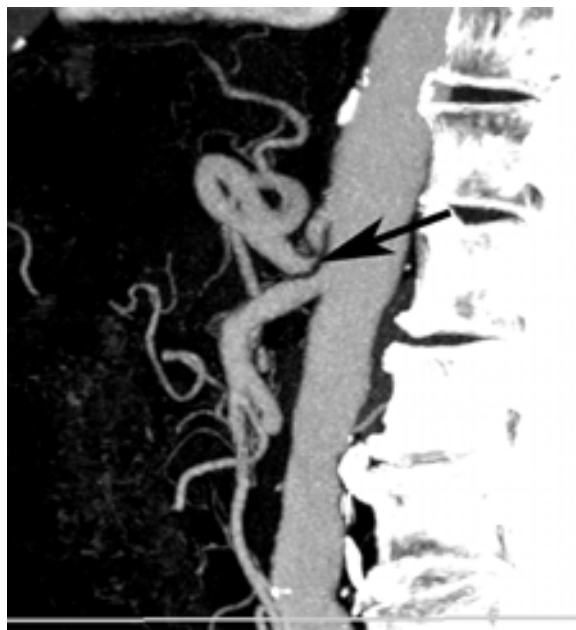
A computed tomography scan demonstrates filling defect in the proximal celiac artery. This is due to extrinsic compression by the arcuate ligament in a case of median arcuate ligament syndrome. The dark arrow shows the characteristic “hook-shaped” appearance.
